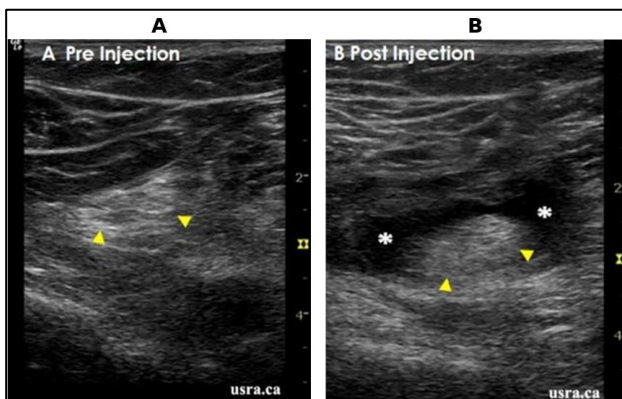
(A and B): Ultrasonogram showing deposition of local anaesthetic (stars) around the sciatic nerve. (A and B) show local anaesthetic spread around the nerve at two levels.
